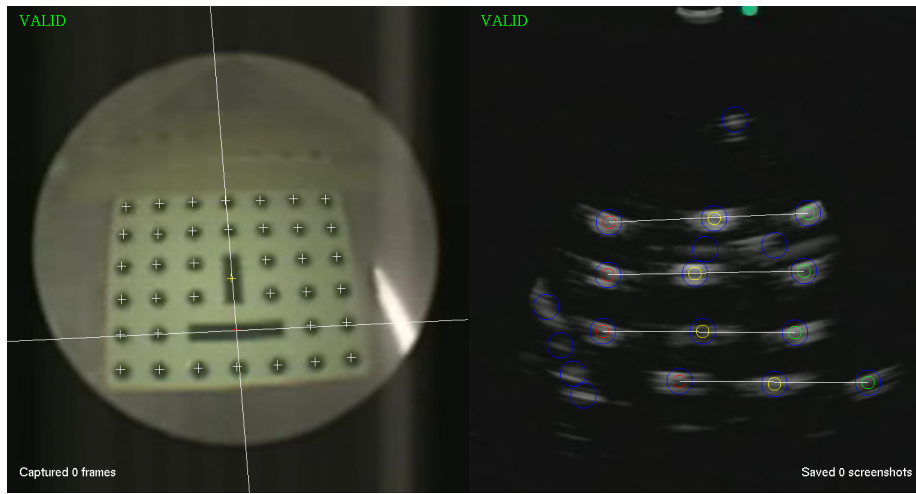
User interface during endobronchial ultrasound and video calibration, with camera image of calibration pattern (left), and ultrasound image of Z-fiducials (right). Image courtesy of Dressel *et al.* [Dres 10].
